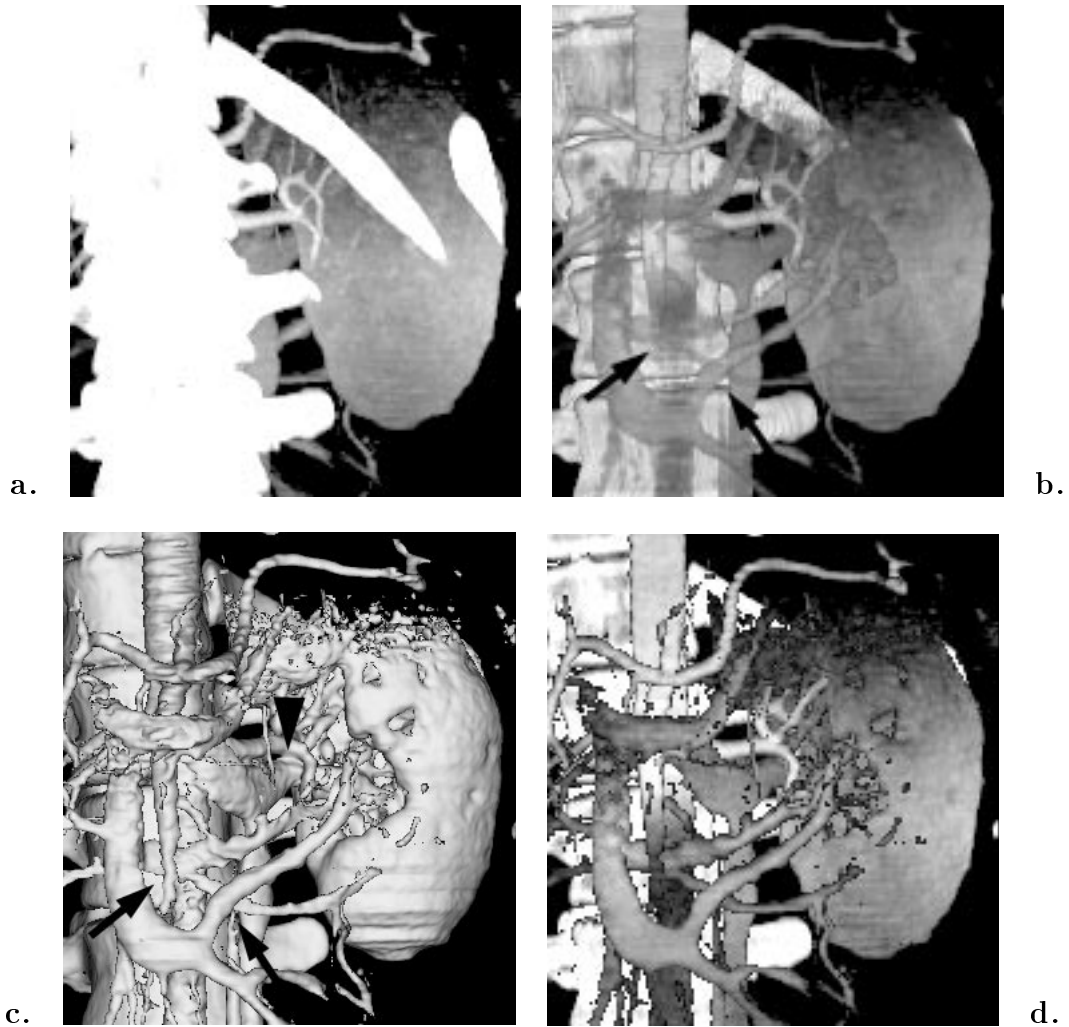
Rendered images using 3D data of CT angiography around a left kidney. a: MIP (maximum intensity projection) image. b: VR (volume rendered) image. Densitometric information is clearly depicted while the vessel boundaries and the spatial interrelations between vessels are unclear (shown by arrows). Slight banding effect (stripe pattern artifact) appears on rib surfaces. c: SSD (shaded surface display) image. Geometrical information on the superior mesenteric veins is clearly depicted (shown by arrows) while the surfaces of the renal artery and vein are fused (shown by an arrowhead). d: LMIP (local maximum intensity projection) image.
